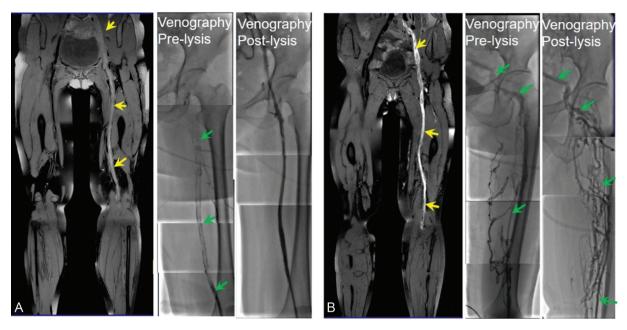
Representative cases with different immediate thrombolysis outcomes. The thrombi with iso-intense signals on T1-weighted black-blood MR images are successfully dissolved (A), as indicated by pre-/post-lysis venography, whereas those with hyper-intense signals are not (B). Arrows denote the thrombi.
